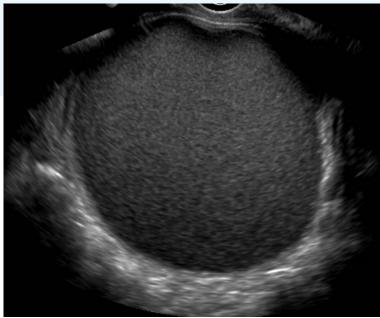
Gray scale ultrasound transvaginal left ovary demonstrates unilocular cyst with homogenous low-level echoes.
